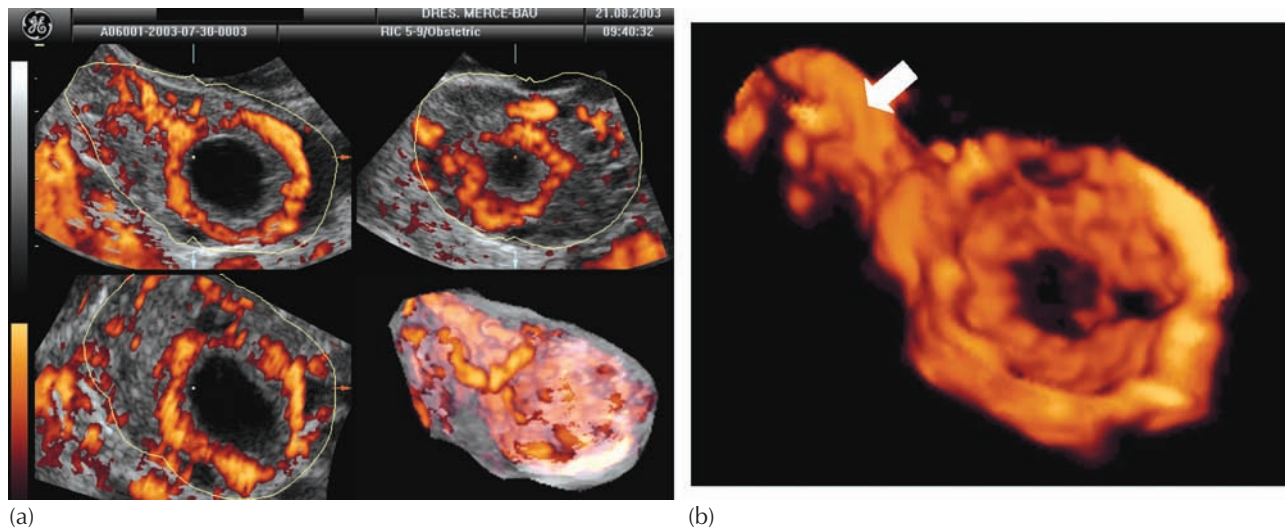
Luteal circulation assessment during early pregnancy by 3D power Doppler angiography. (a) Acquisition technique applying the VOCAL software. (b) Three-dimensional angiographic rendering of the vascular network in a gestational corpus luteum. The arrow points to the helical artery.
